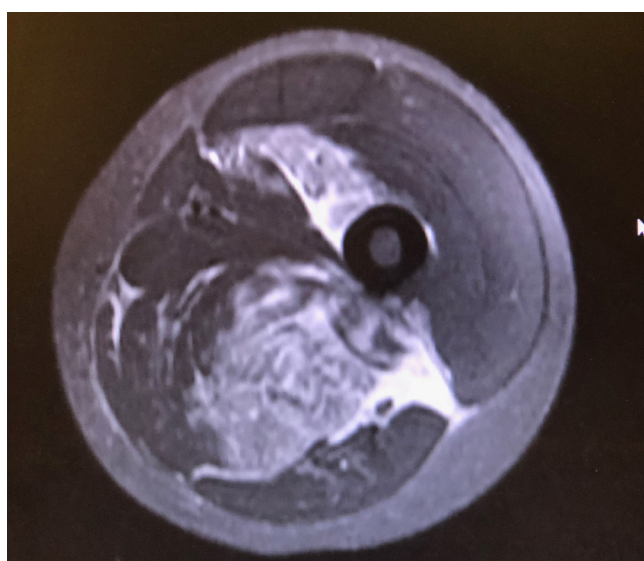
Axial STIR sequence MRI of middle left thigh showing extensive edema in posterior compartment and fluid collection around sciatic nerve.
